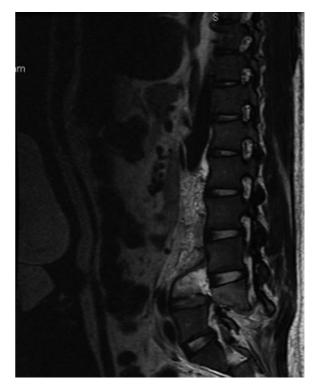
Magnetic resonance imaging, sagittal view, showing integrity of the intervertebral disc L4–L5.
